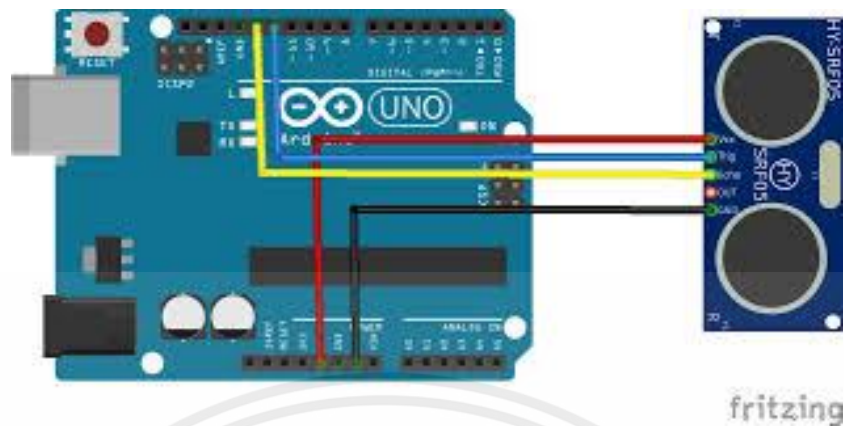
Ultrasonic sensor HC – SR05 with Arduino board [28]
